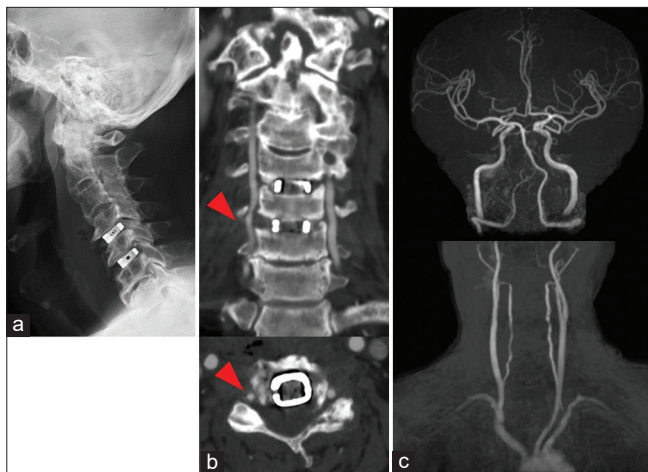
Postoperative images. (a) X-ray images showing ACDF are successfully performed. (b) MIP image of CE-CT showing resection of the osteophyte and no stenosis in the right VA (arrowhead). (c) MRA showing improvement of the blood flow of the right VA.
